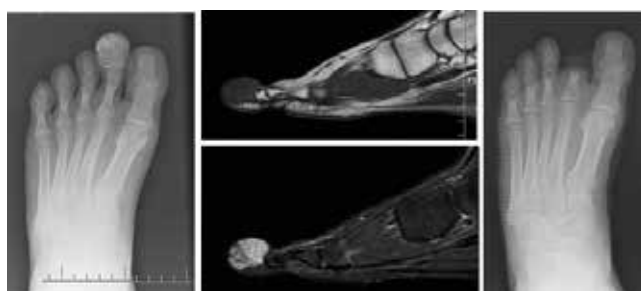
Case no 2: chondrosarcoma of the second finger of the foot. Expansile, mixed lytic-sclerotic tumoral lesion containing chondroid matrix with relatively intact borders leading to sclerosis and thinning of the cortex at the level of second distal phalanx of the foot is viewed. The tumor with these characteristics is radiologically resembling enchondroma. a) preoperative ap x-ray b and c) preoperative sagittal MRI d) postoperative ap xray
